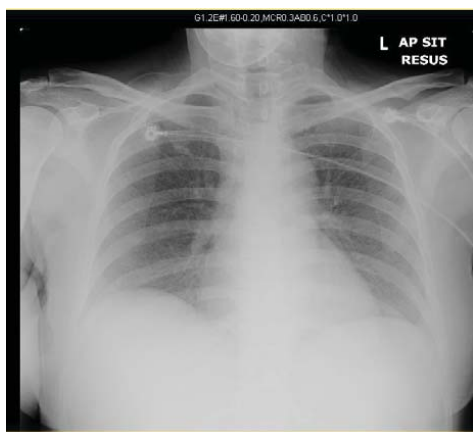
Chest x-ray performed at admission.
